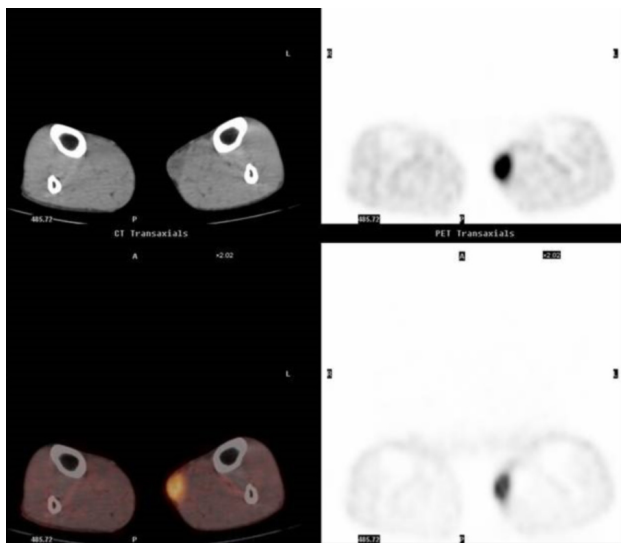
Coregistration of transaxial CT images with ¹⁸FDG PET images. Intense pathological FDG uptake (SUV 9.1) is present on initial ¹⁸FDG PET examination coregistering with superficial soft-tissue mass, consistent with biologic tumor activity.
